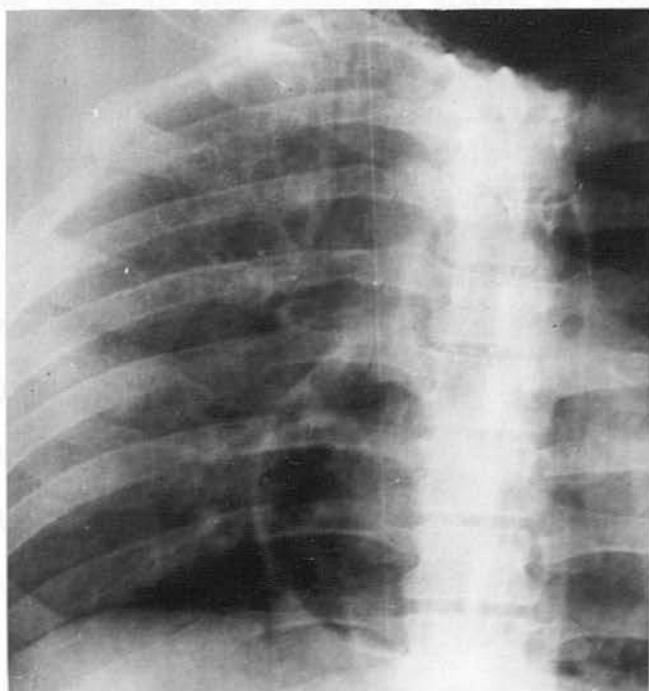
(Case 1 - T.R.) - Post-mortem Radiograph. Large translucency medially in the right lower lobe, found to be a lung cyst. Extensive mediastinal emphysema.
